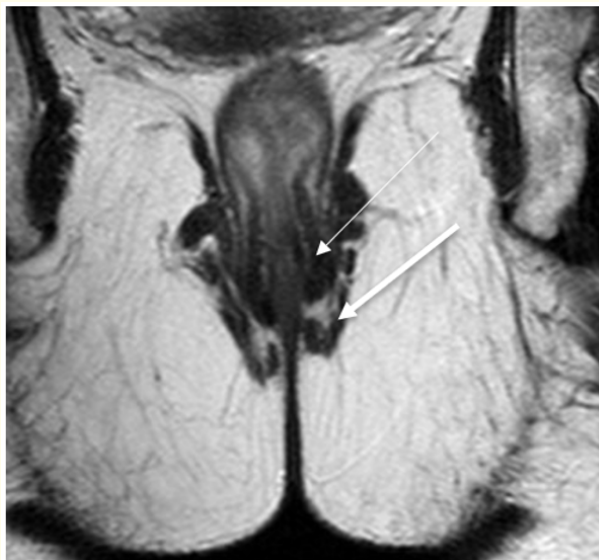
Midcoronal T2 w TSE MR image of the anal canal showing the normal feature of the internal anal sphincter (thin arrow) and that of the external anal sphincter (thick arrow) in exquisite detail.
